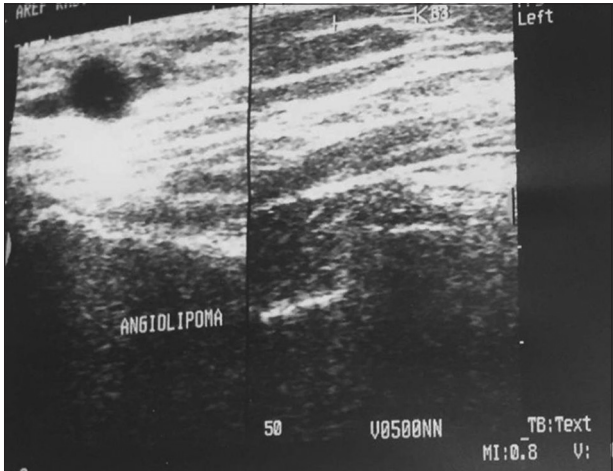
Soft-tissue swelling ultrasonography showing angioliipoma
